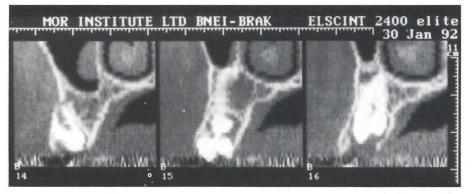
CT reconstruction of the maxilla at the buccopalatal plane clearly demonstrates that the mesial tooth is adjacent to, but separated from the nasal cavity and maxillary sinus, and is close to the buccal cortical bone plate, allowing safe surgery from a buccal approach.
